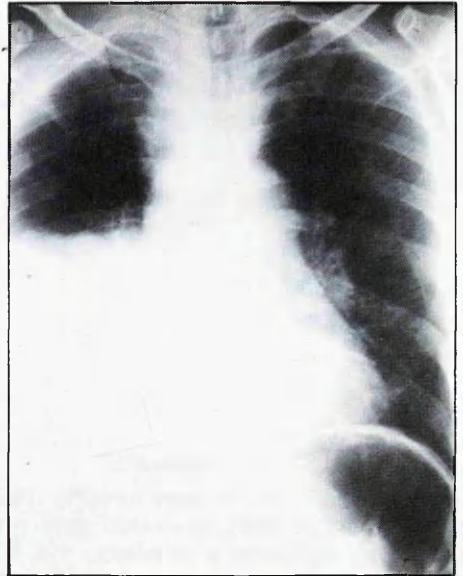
59 years old with severe cough, dyspnea and haemoptesis. Chest X-Ray showed massive pleural effusion.
